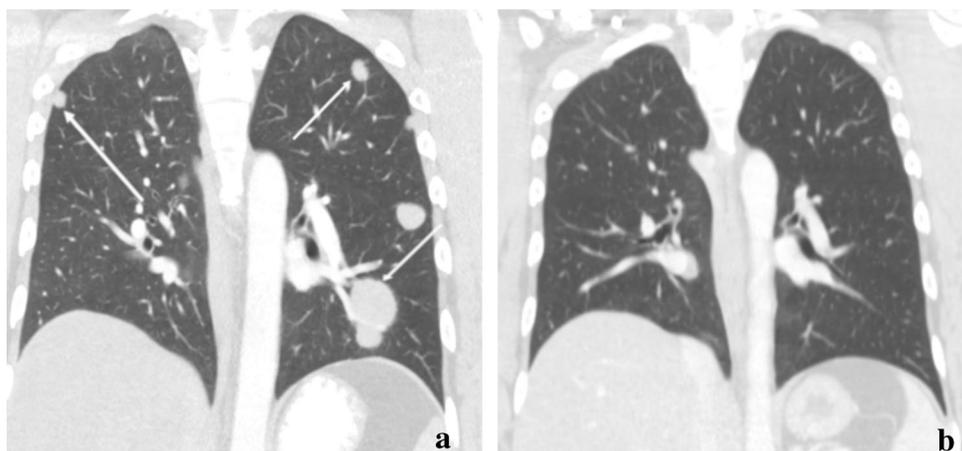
34-year-old male with mixed NSGCT of embryonal, yolk sac, and teratoma elements. Coronal CT of the chest 2 months after orchiectomy (a) was performed after AFP had risen from 33 to 43 ng/mL and HCG had risen from 21 to 30 IU/mL. Multiple metastatic
